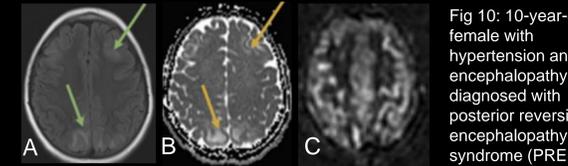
10-year-old female with hypertension and encephalopathy diagnosed with posterior reversible encephalopathy syndrome (PRES). Mildly expansile posterior predominant FLAIR hyperintensity (A,D) and facilitated diffusion (B,E). Hyperperfusion in the occipital lobes bilaterally (C,F).
